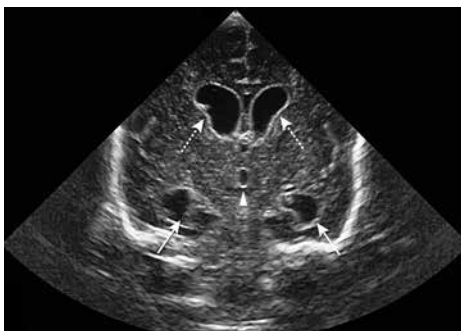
Coronal ultrasound scan in preterm infant (gestational age 29 wk) with post hemorrhagic ventricular dilatation, showing dilated frontal (dotted arrows) and temporal (arrows) horns of the lateral ventricles and dilated third ventricle (arrowhead). Also showing echogenic ventricular lining, representing ventriculitis, as often seen in cases with intraventricular hemorrhage.
